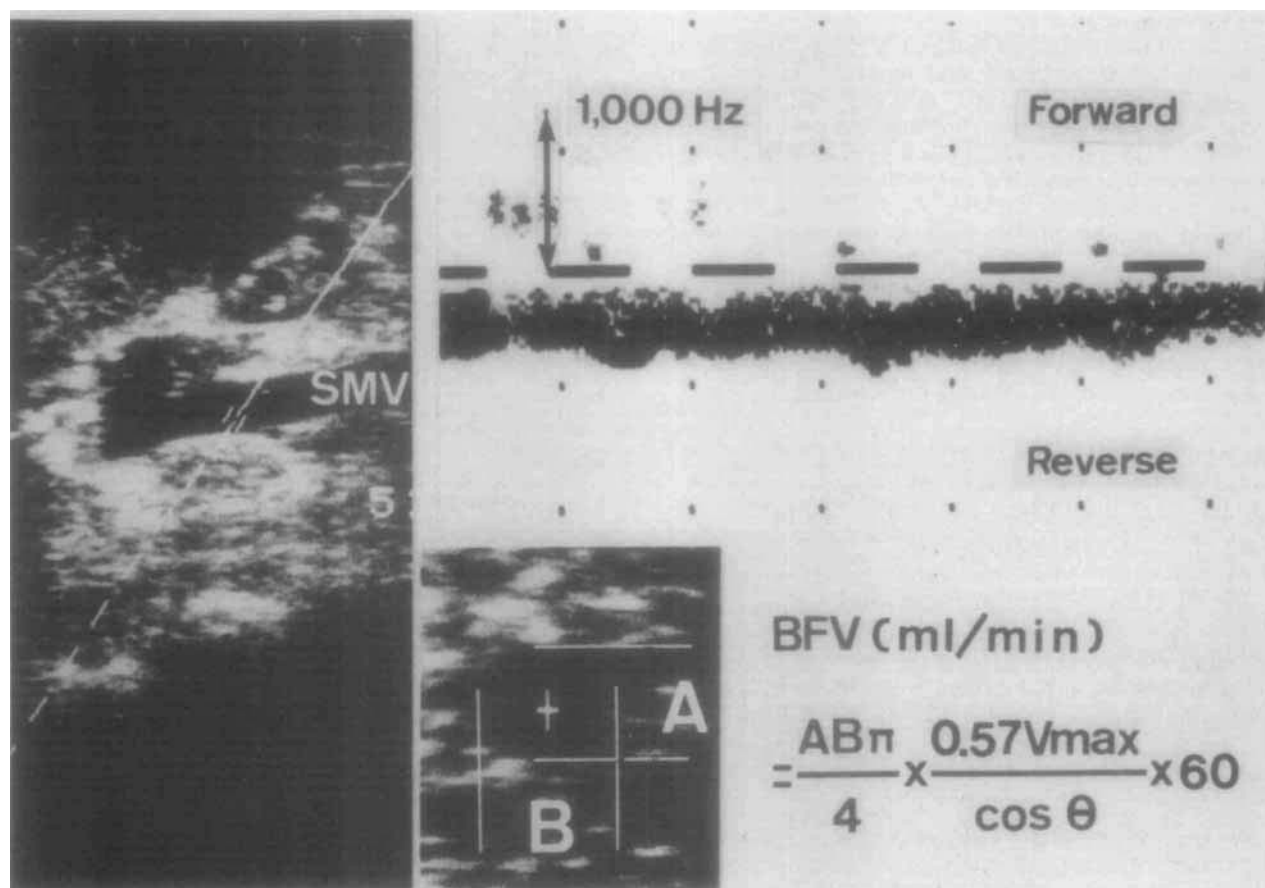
Measurement of the blood flow volume (BFV) using the ultrasonic duplex system. SMV = superior mesenteric vein.
